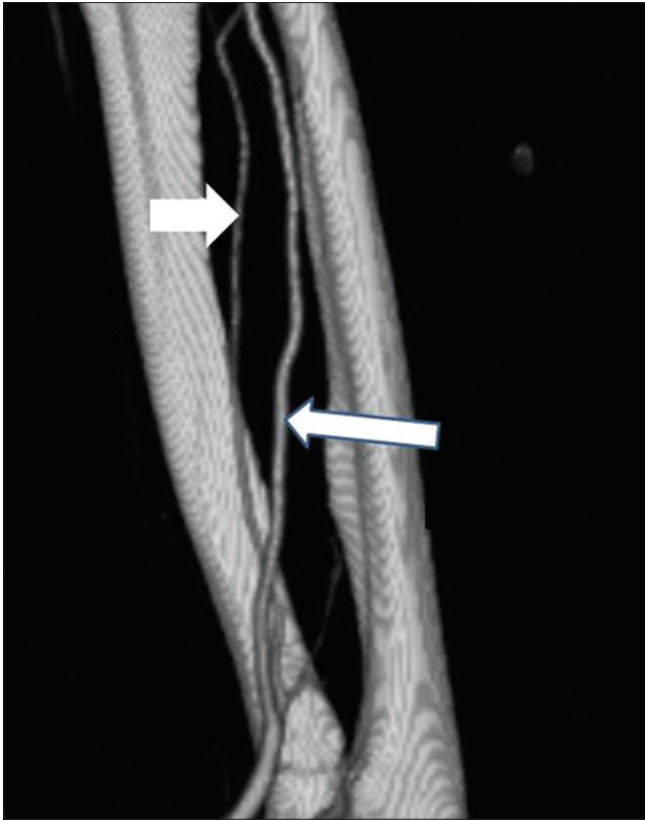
Anterior projection of computed tomography demonstrates a persistent median artery (long arrow). The radial and ulnar artery are absent. Interosseal artery (short arrow) separates from the persistent median artery
